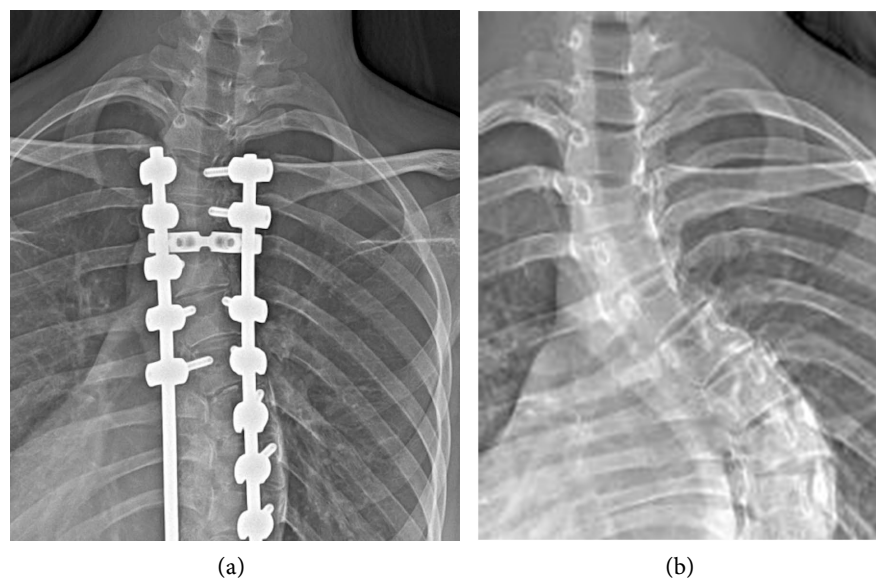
Evaluated screws. (a) First, screws inserted to the concave side of the proximal thoracic curve were identified. (b) Then preoperative CT was retrospectively evaluated for the pedicles with the pedicle screws inserted. CT: Computed Tomography.
